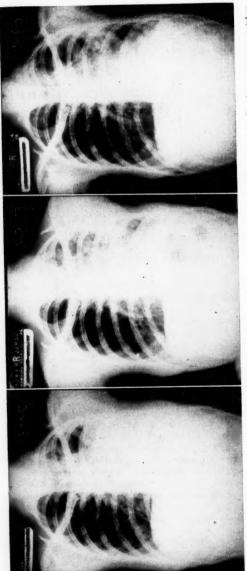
Case 2. Roentgenogram taken after one month on antihistamines. There is considerable clearing of the left lower lobe as well as some of the exudative reaction in the upper lobe on this same side.
